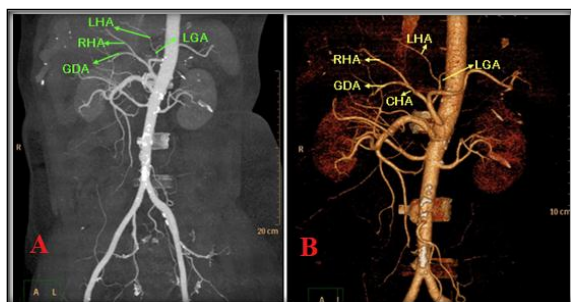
Coronal MIP image (a) and 3D reconstructed image (b) from CT angiographic data showing Type II of Michels’ classification with replaced LHA arising from the LGA and the CHA dividing into the RHA and GDA
